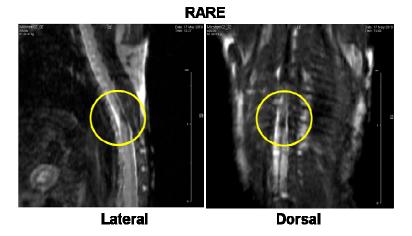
In vivo MR imaging (RARE sequences) of SPIO-labelled NSCs injected intravenously in experimental model of traumatic spinal cord injury. Sagittal and dorsal MRI images of the spinal cord just at 7 days post cell injection showed the presence of T2 hyporintense signal in the dorsal portion of the spinal cord (yellow circles).
